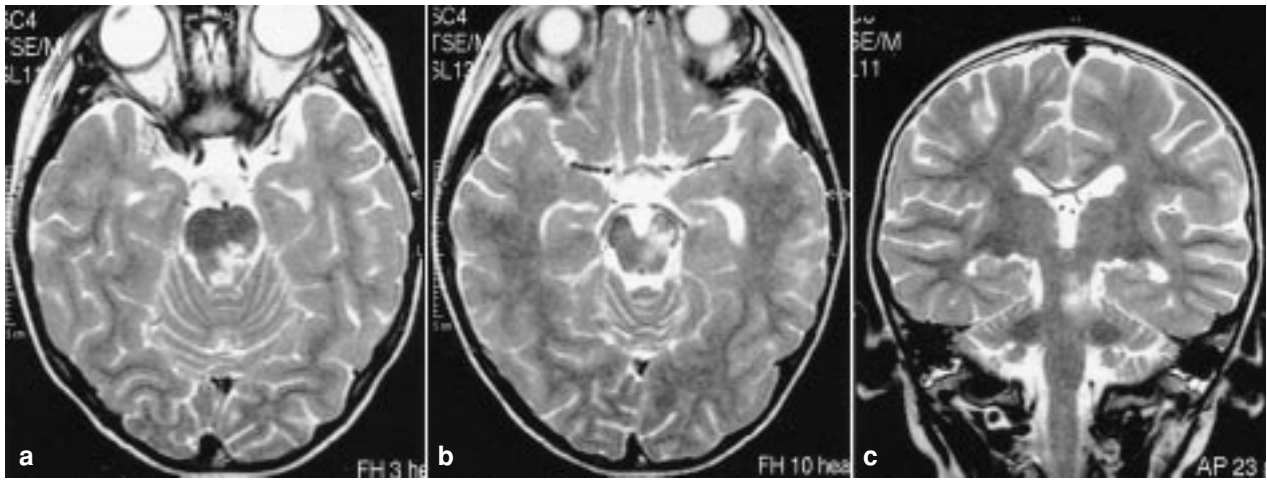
Axial (a, b) and coronal (c) T2-weighted magnetic resonance images showing an irregularly shaped high intensity area in the tegmentum of the lower left midbrain down to the upper pons, including the left cerebral peduncle and extending contralaterally
